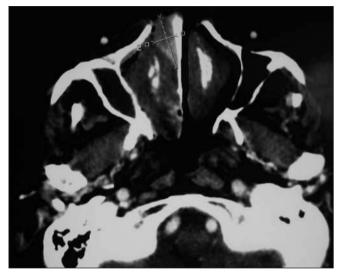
CT scan showing a tumour formation originating from the right septal region diagnosed as sinosinusal melanoma.
